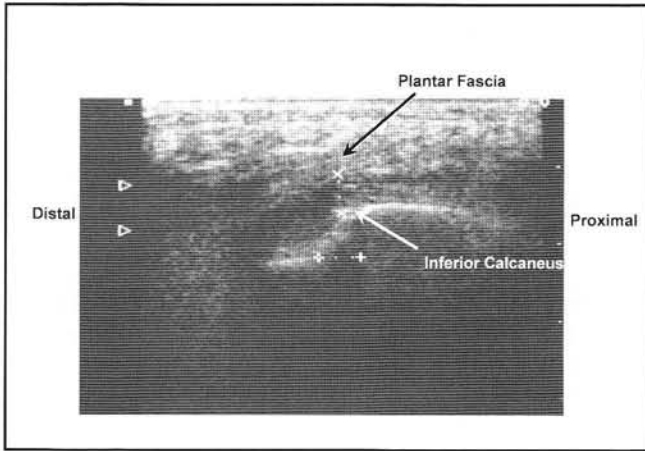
The ultrasound unit provides continuous visualization of the treatment area.
